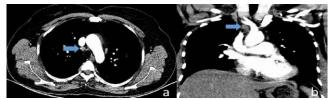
Enlarged lymphadenopathies observed in the right paratracheal area in the axial (a) and coronal sections of the computed tomography (b)
